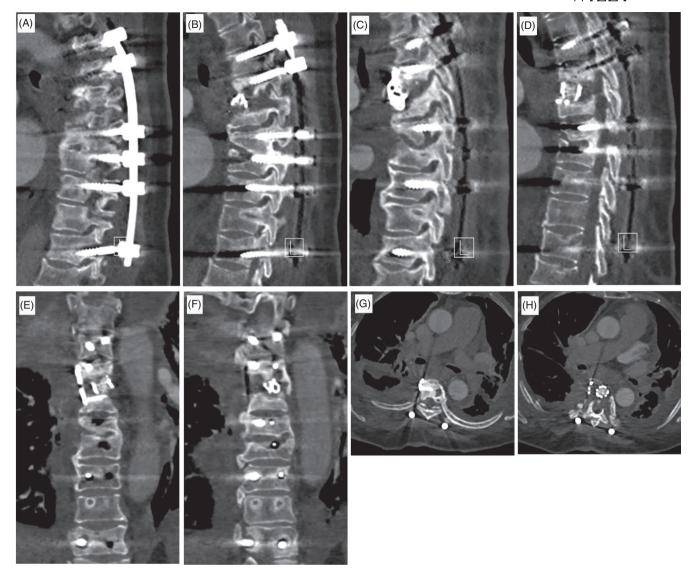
Postoperative CT examination performed during the third surgery. (A and B) The nail bar system is fixed well in the sagittal plane. (C and D), The titanium cage and the plate system are aligned correctly in the sagittal plane. (E and F) The titanium cage and the plate system are fixed well in the coronal plane. (G and H) The titanium cage and the plate system are aligned correctly in the system are aligned correctly in the coronal plane. (G and H) The titanium cage and the plate system are aligned correctly in the coronal plane.
